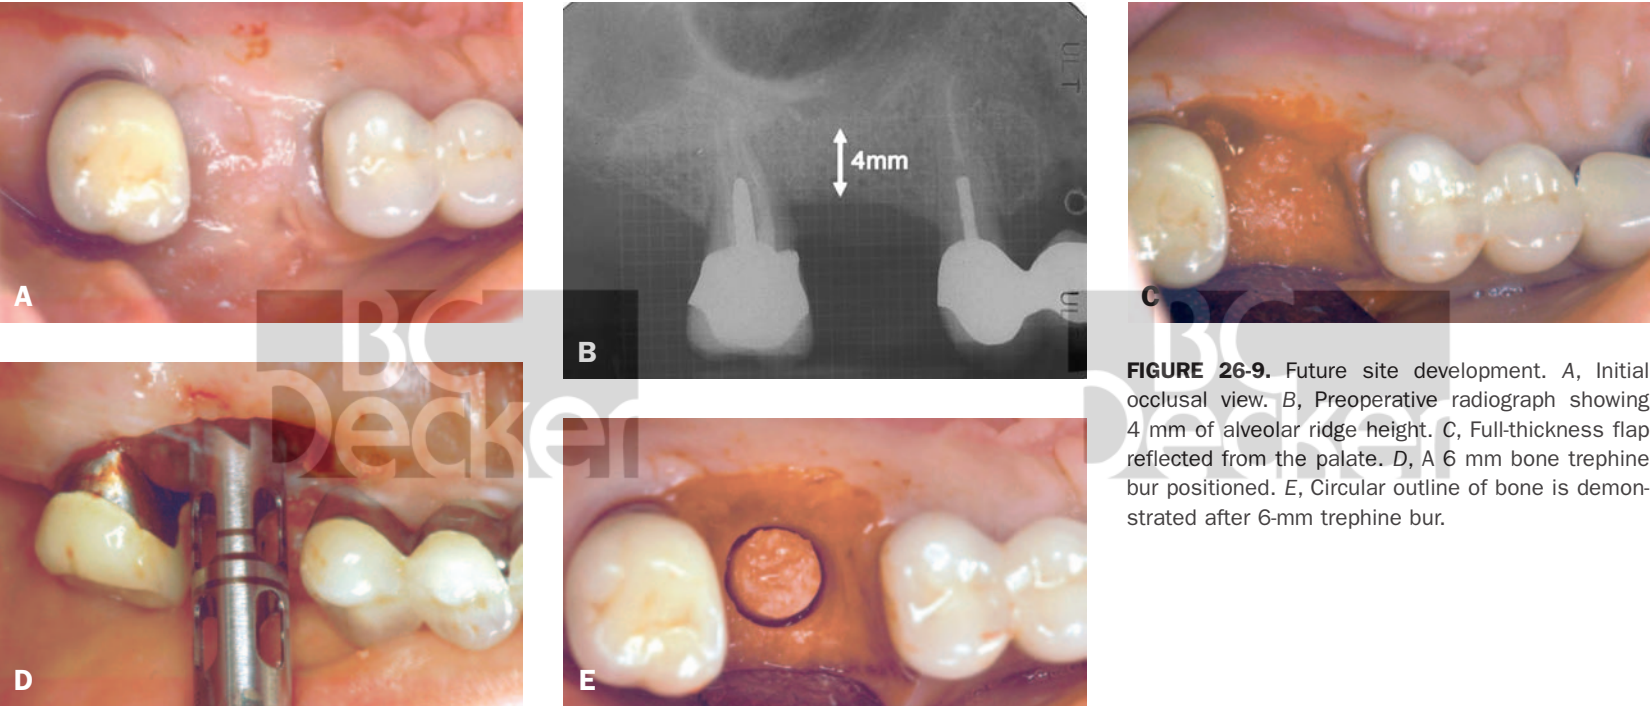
Future site development. A, Initial occlusal view. B, Preoperative radiograph showing 4 mm of alveolar ridge height. C, Full-thickness flap reflected from the palate. D, A 6 mm bone trephine bur positioned. E, Circular outline of bone is demonstrated after 6-mm trephine bur.
